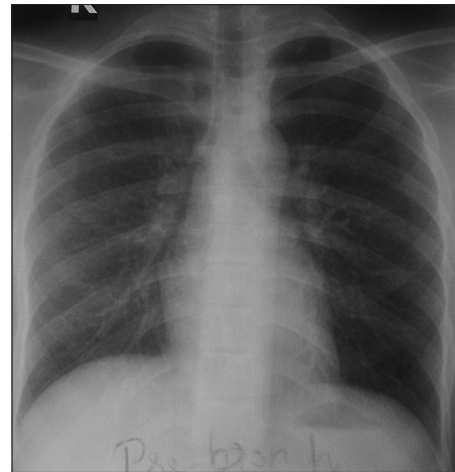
Chest X-ray showing bilateral nodular opacities
